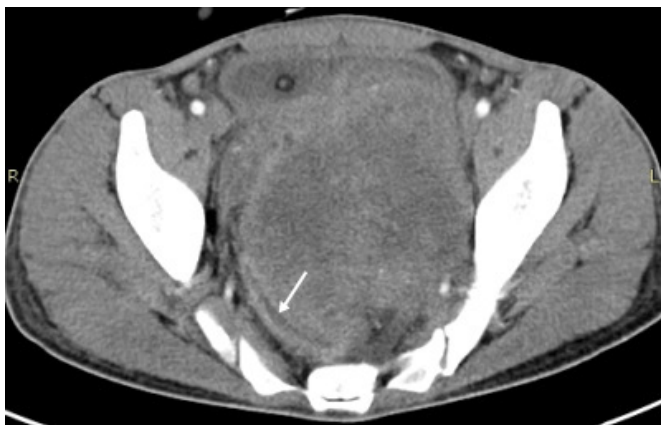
Contrast enhanced CT scan showing a large, fairly well defined, heterogeneously enhancing mass measuring 140 x 100 cms, in the pelvis. It is abutting the rectum, compressing and displacing it posterolaterally, towards right
